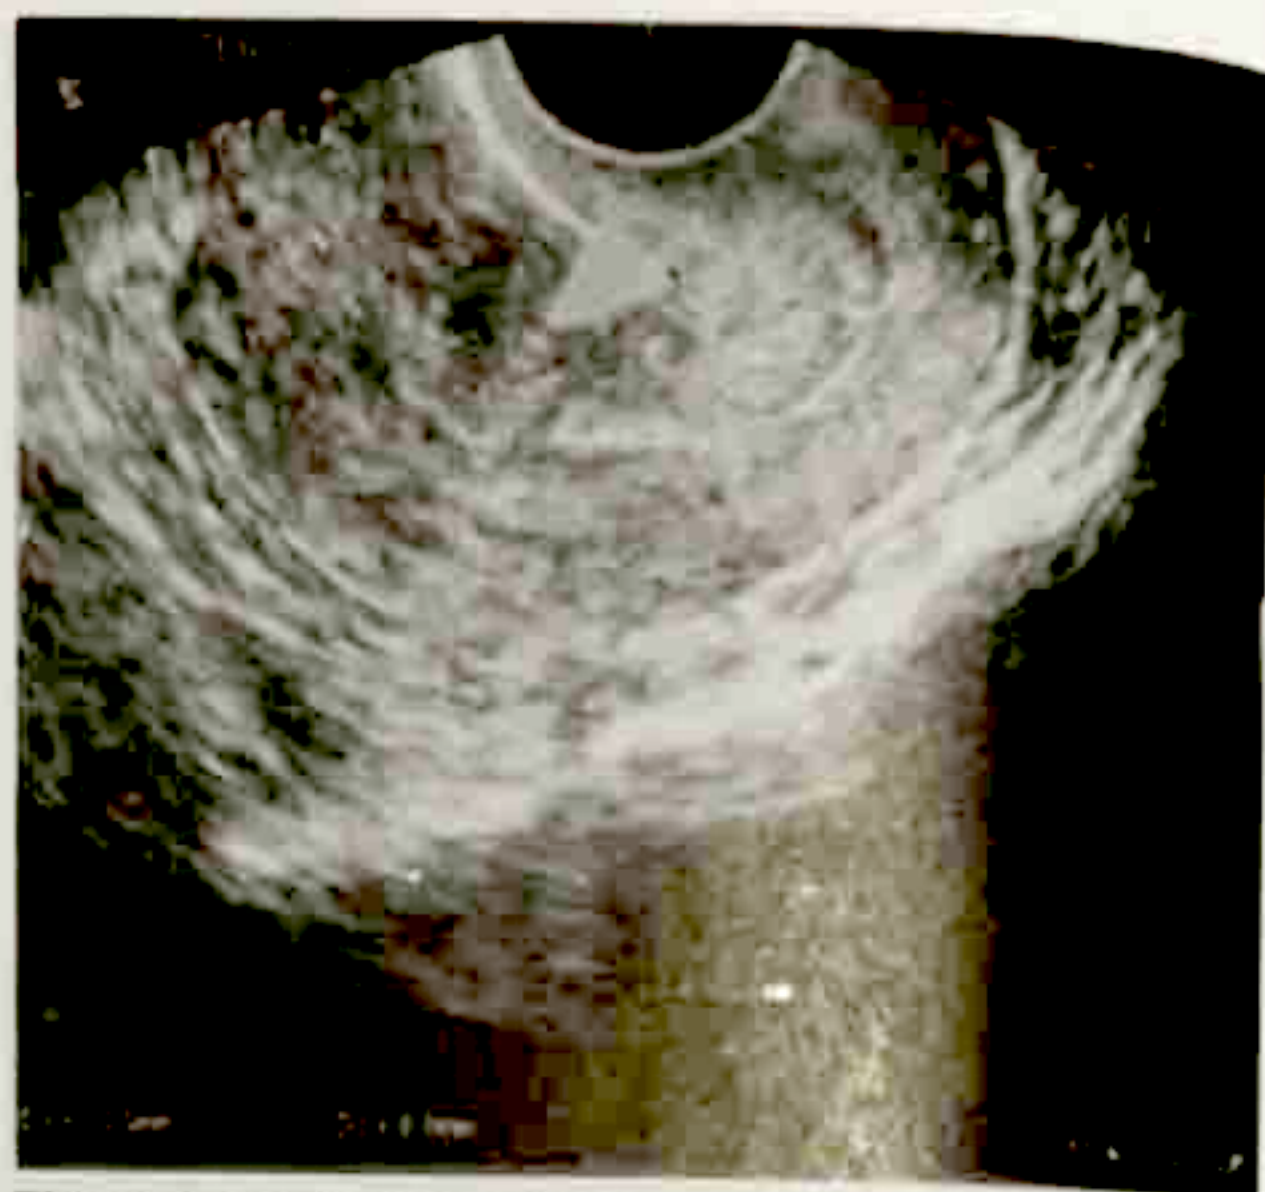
Transvaginal ultrasound showing septate uterus with myoma nodule (▲) at left cornu, measuring 1cm x 0.8cm.
